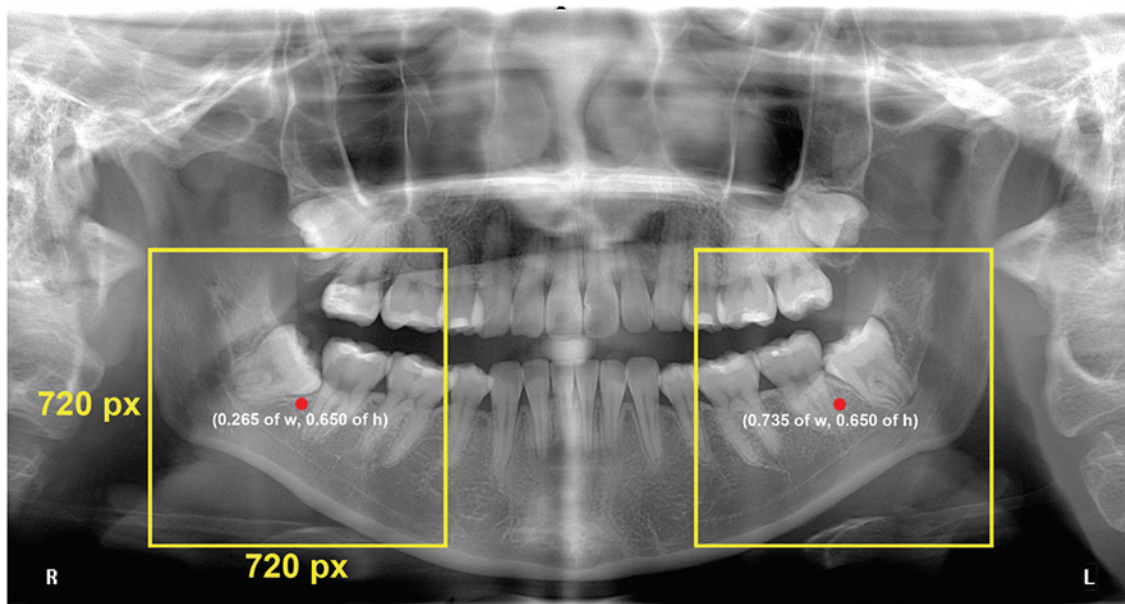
Panoramic radiographs were processed and cropped. The ROI centers for the left tooth size were 0.265 in the width and 0.650 in the height. The ROI centers for the right tooth size were 0.735 in the width and 0.650 in the height. The ROI square images have 720 pixels for width and height.
